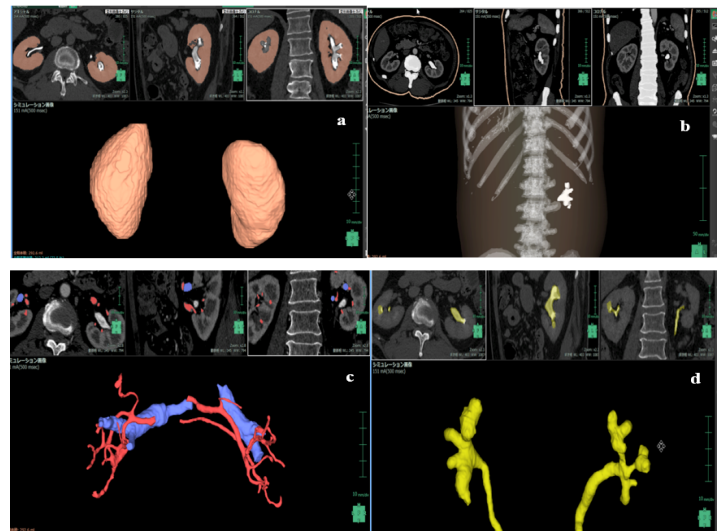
(a-d): Anatomical segmentation from preoperative CT image. (a) Extraction of renal parenchyma; (b) Extraction of kidney stones; (c) Extraction of renal blood vessels (renal artery, renal vein); (d) Extraction of urinary tract.
